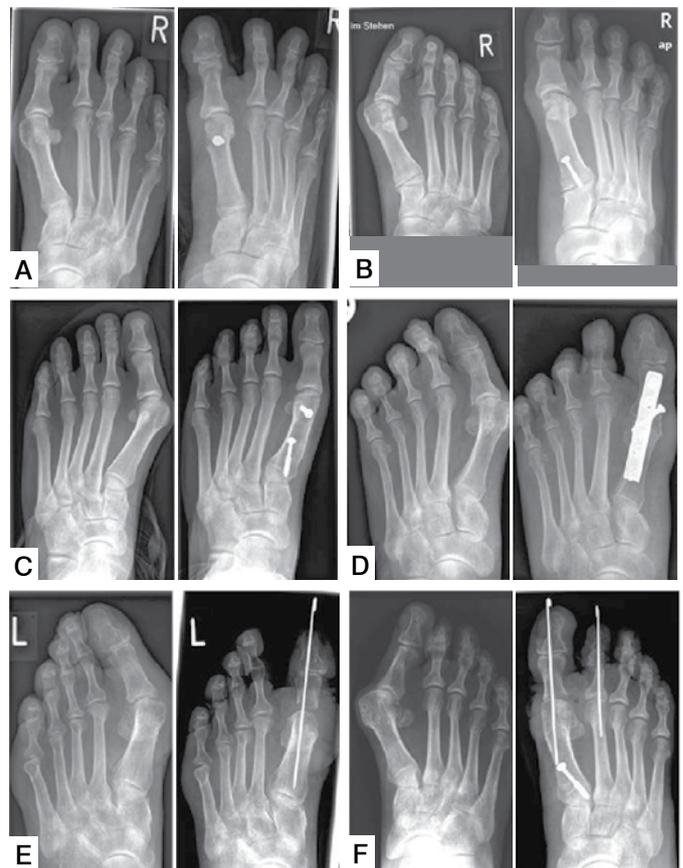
Pre- and postoperative radiographs 6 weeks after hallux valgus correction surgery. a) chevron osteotomy metatarsal-I; b) basal osteotomy of metatarsal-I with distal soft tissue procedure; c) distal and proximal double osteotomy of metatarsal-I; d) arthrodesis of metatarsophalangeal-I joint; e) resection arthroplasty of metatarsophalangeal -I joint; f) combined resection arthroplasty and basal osteotomy of metatarsal-I
